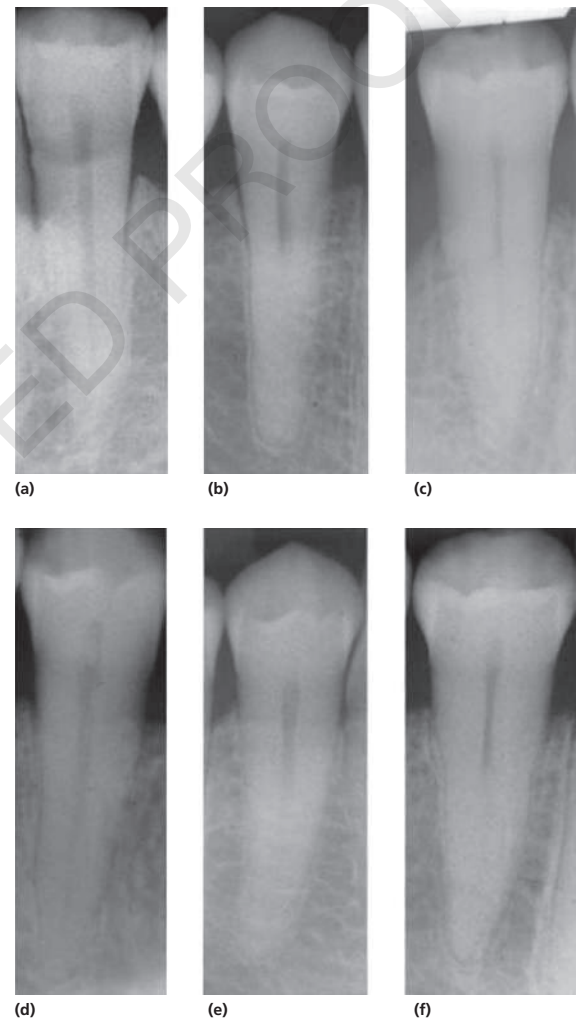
Periapical radiographs of a premolar taken of a male patient at three times over a 40-year period. (a) Mandibular first premolar at age 33. The root canal system can be seen to the apex of the tooth. (b) The same tooth at age 52. (c) The same tooth at age 73 years. The same pattern is seen in a second patient at the same time frames (d, e, f). Courtesy of Woo, 2001.
